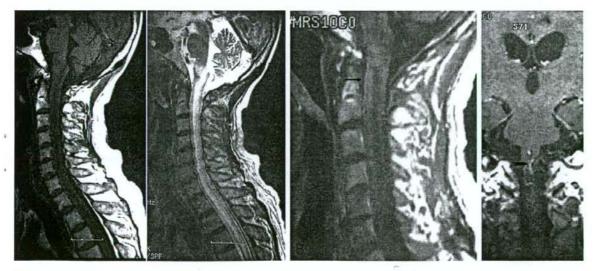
Magnetic resonance imaging, (A) intramedullary lesion (mainly in the center of the cord) with low intensity on the T1-weighted image (left panel) and high intensity on the T2-weighted image from the medulla oblongata to the spinal cord at the level of fourth vertebra (right panel). The lesion is accompanied by marked edema, (B) The ventral parenchyma presents mild and irregular enhancement (\rightarrow), (C) a dilated vessel along the ventral surface of the upper cervical cord (\Longrightarrow).
